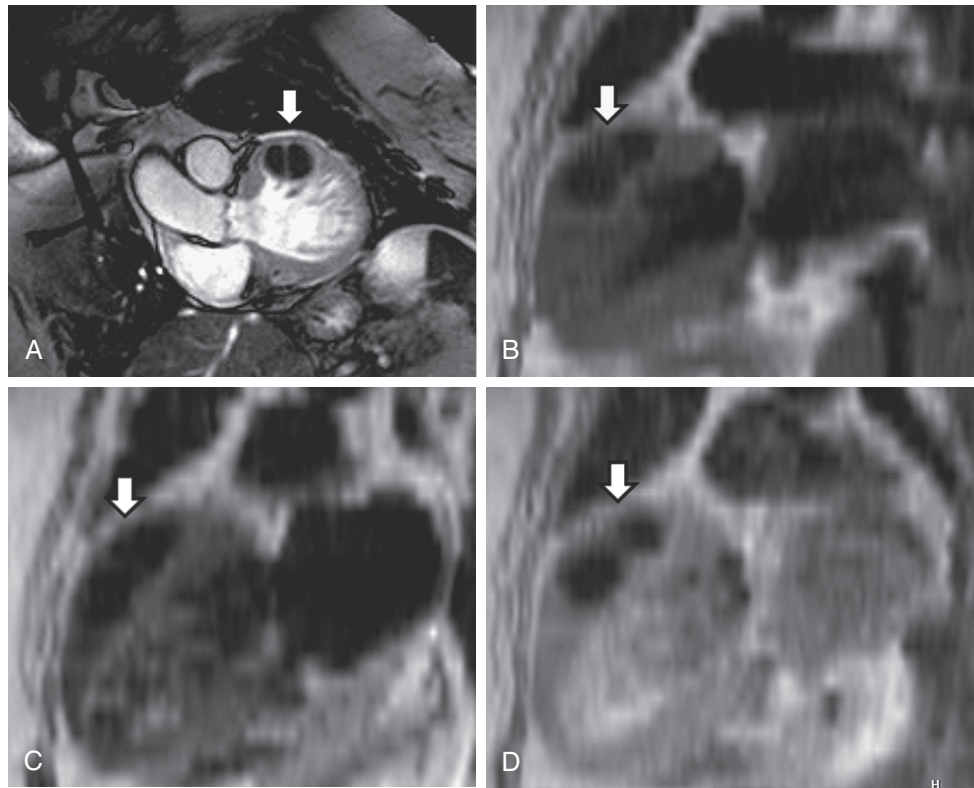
■ Myocardial fibroma. A, Steady-state free-precession cine cardiovascular magnetic resonance image of the left ventricular outflow tract shows a well-circumscribed intramyocardial mass with low signal (*arrow*). The mass had low signal on T1 weighting (B), T2 weighting (C), and T1 weighting after administration of contrast material (D) on spin-echo imaging in the two-chamber view (*arrows*), indicating calcification of the mass. These findings are consistent with a fibroma.
